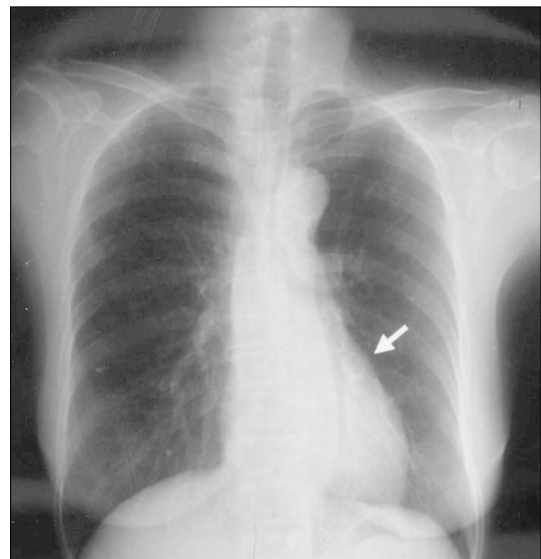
Initial posteroanterior chest X-ray showed normal cardiac size without parenchymal lung lesion. At two third portion of left cardiac border, single calcified nodular lesion (arrow) was seen.
